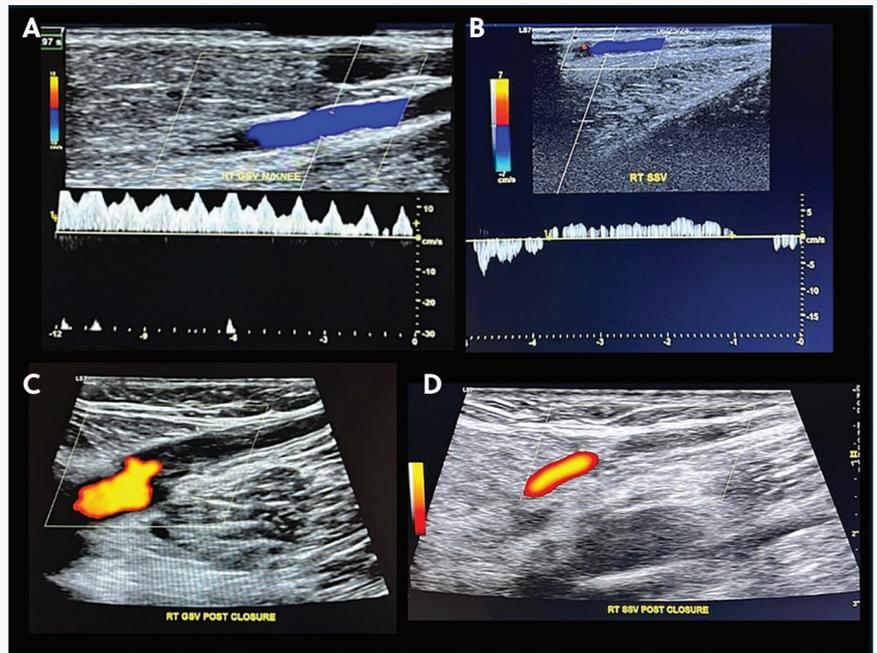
Duplex ultrasound of the right GSV and SSV before (A, B) and after (C, D) VenaSeal system treatment. Figure 1A and 1B demonstrate significant reflux, while Figure 1C and 1D demonstrate complete closure, with no reflux in the treated veins.
